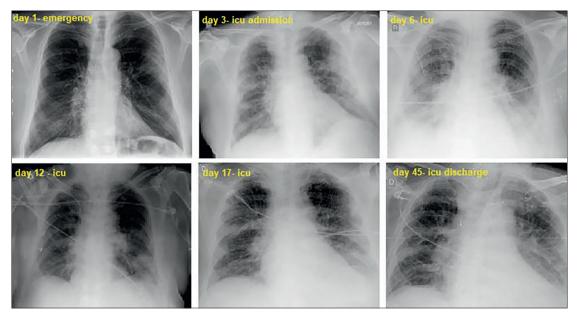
Chest x-ray evolution
